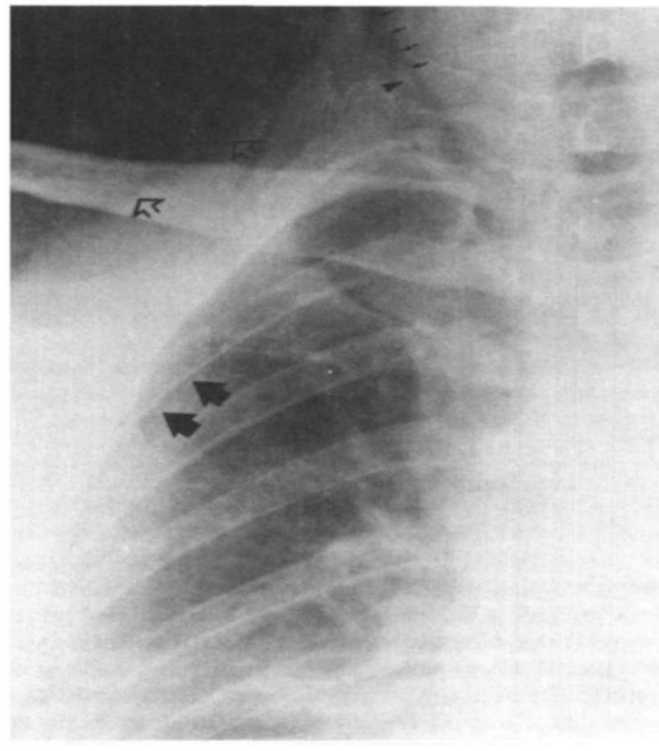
Case #3: Anteroposterior chest x-ray during expiration, showing small right pneumothorax (large, solid arrows), pneumomediastinum with air at the apex of the right lung extending into the neck (small, solid arrows), and subcutaneous emphysema of the soft
